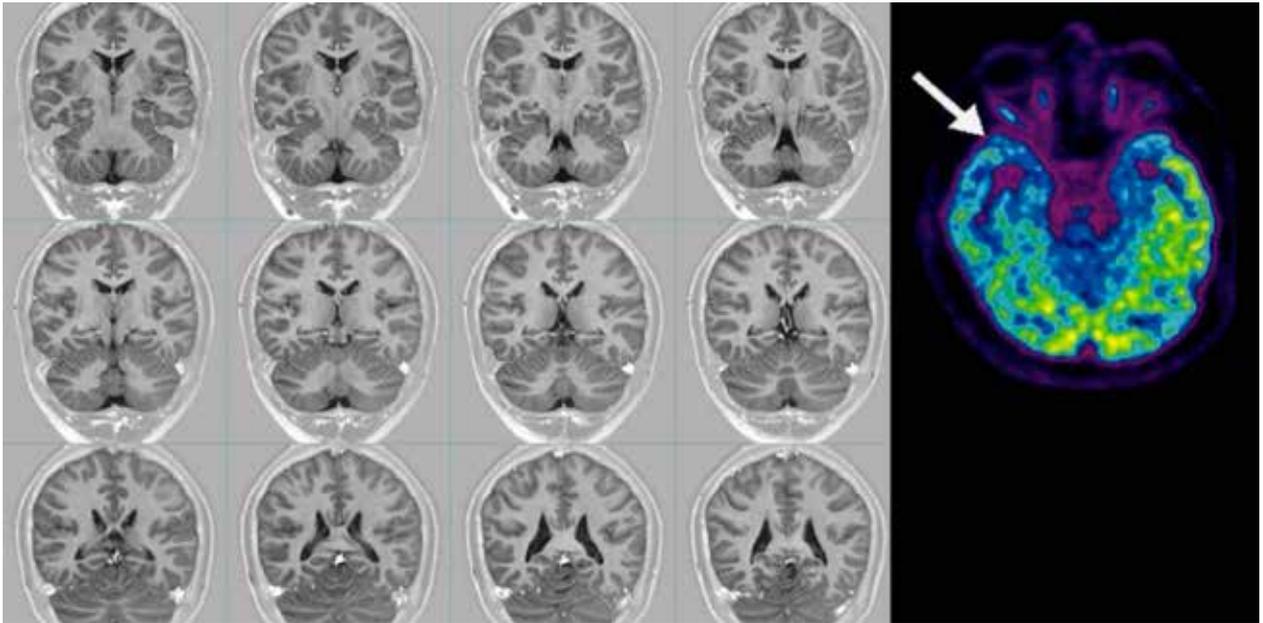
T1 IR MRI sequence with normal findings and FDG-PET showing hypometabolism in the temporal lobe.
